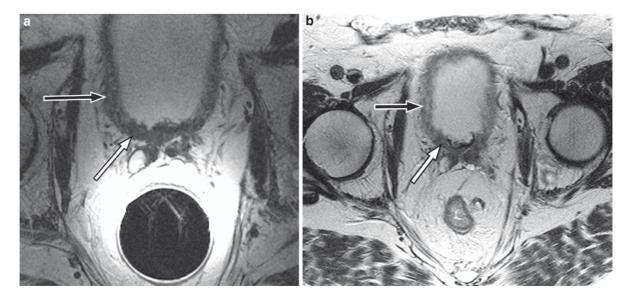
(a–b) Prostate tumor invading the bladder wall on axial T2-weighted images obtained using (a) an endorectal coil and (b) a pelvic coil on a 3 T magnet. Note the complete disruption of the normal layered bladder wall (*black arrow*) by intermediate signal intensity tumor (*white arrow*)
